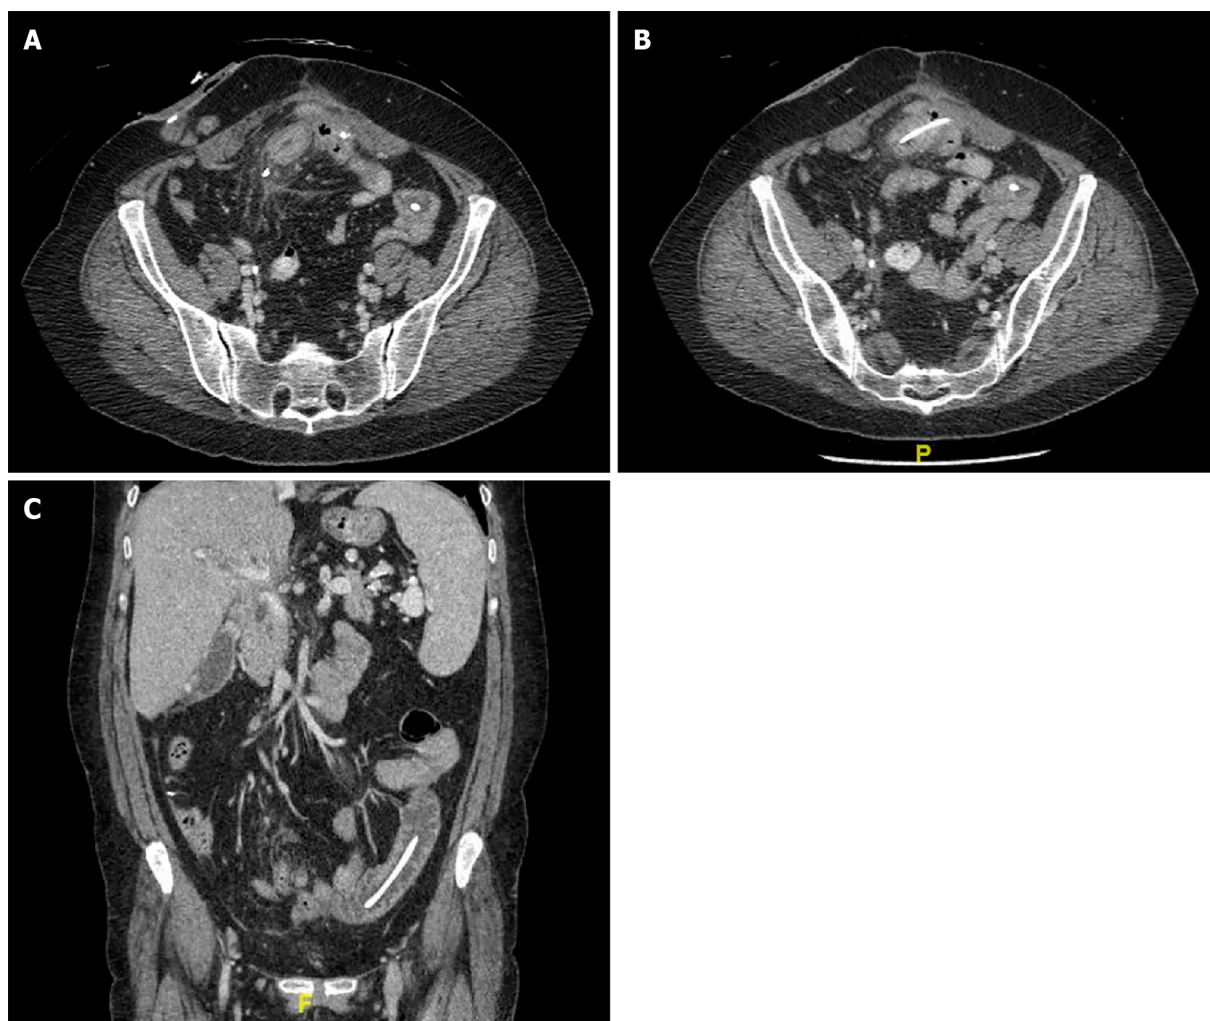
Computed tomography scan. A: Small bowel perforation by migrated biliary stent (Axial view); B: Second migrated biliary stent (Axial view); C: Second migrated biliary stent (Coronal view).
